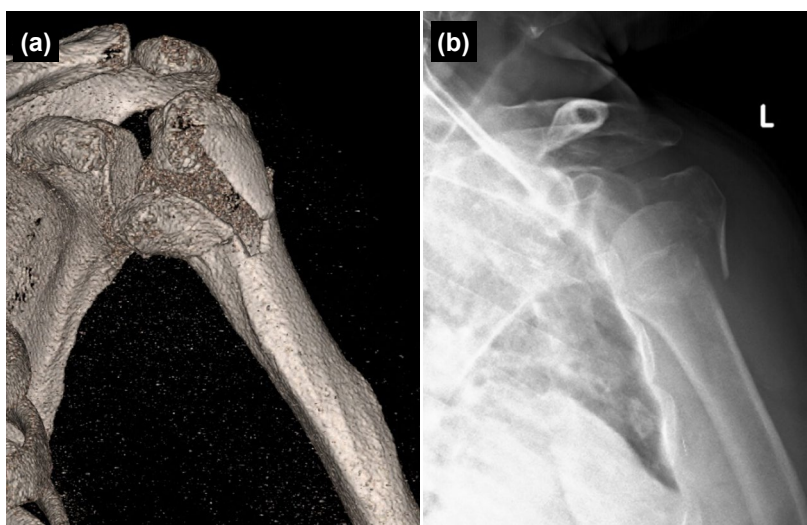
Preoperative imaging of a patient with a proximal humerus fracture treated with open reduction internal fixation and iliac bone autograft augmentation (patient no. 3): (a) 3-D reconstruction image from the preoperative computed tomography scan. (b) Preoperative shoulder AP view radiograph.
